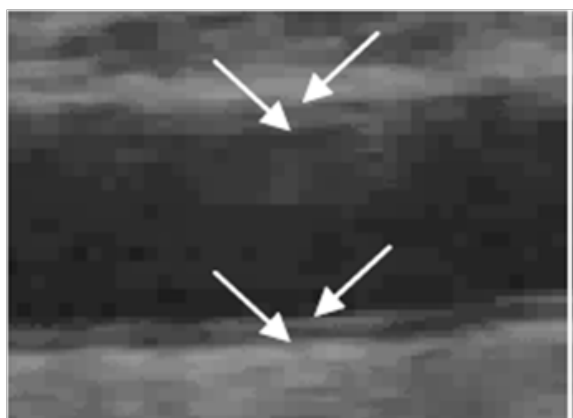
Correspondence of anatomical structure of carotid artery(CA) to the zones of acoustic reflections: above scheme of CA anatomy and ultrasound image of echo zones; below - typical B-scan image of CA. White arrows corresponds to the blood-intima boundary and the second to the outer media-adventitia interface.
